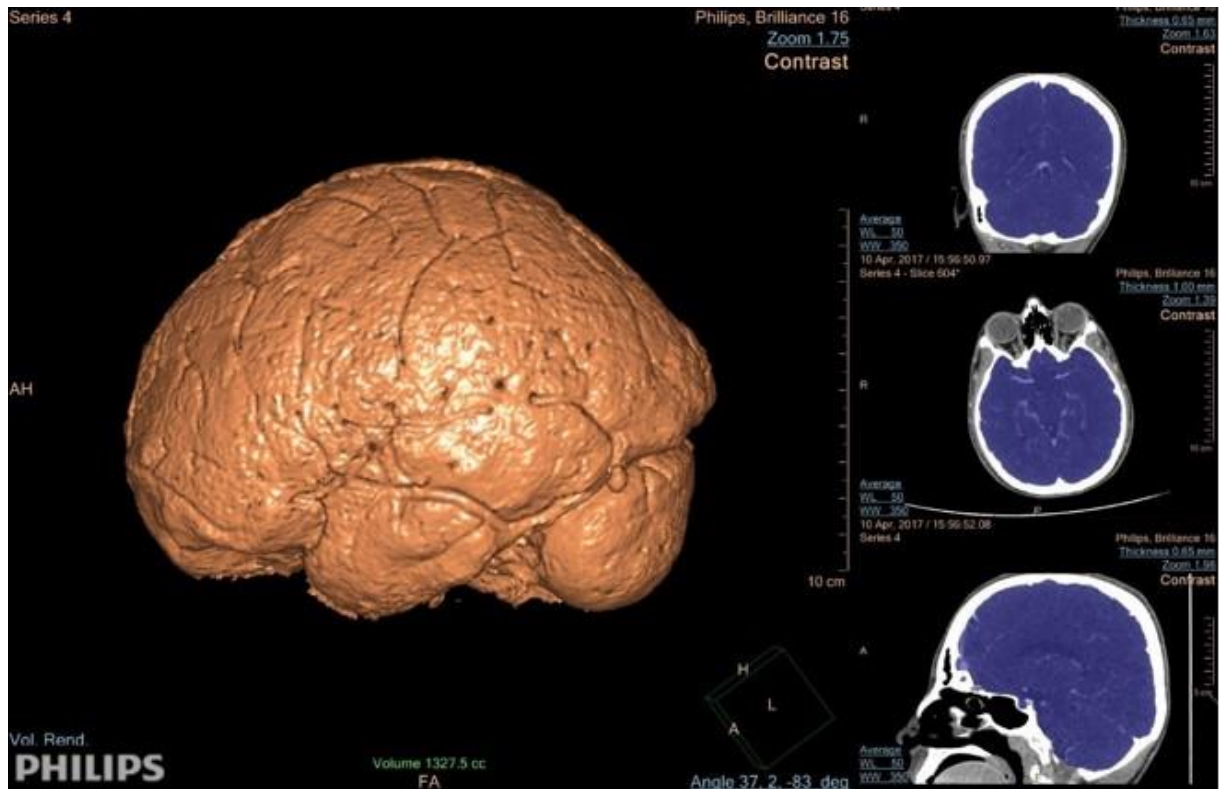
The entire intracranial space is marked in purple on coronal, axial, and sagittal CT images from top to bottom on the right, through the semi-automatic segmentation method. The measurement data and the three-dimensional image of the selected volume are displayed on the left
